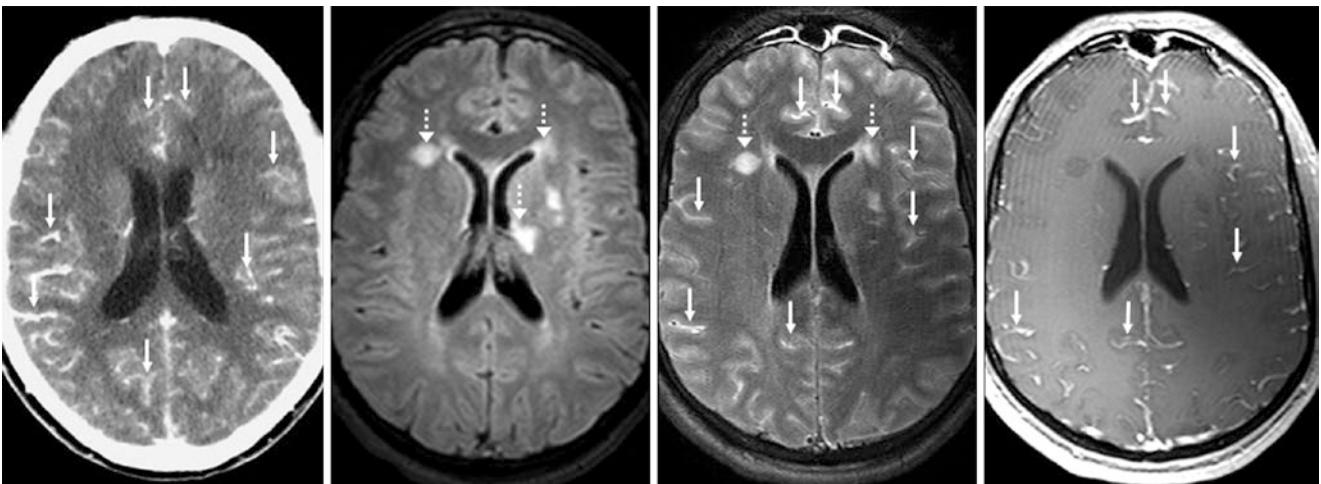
Comparison case of cryptoccal meningitis. A 33-year-old HIV+ man had diffuse LMCE on CECT (*left*). A 3T MRI with FLAIR (*left middle*) and DWI (*not shown*) showed bilateral acute periventricular and basal ganglia infarcts (*dotted arrows*) probably due to vascular
